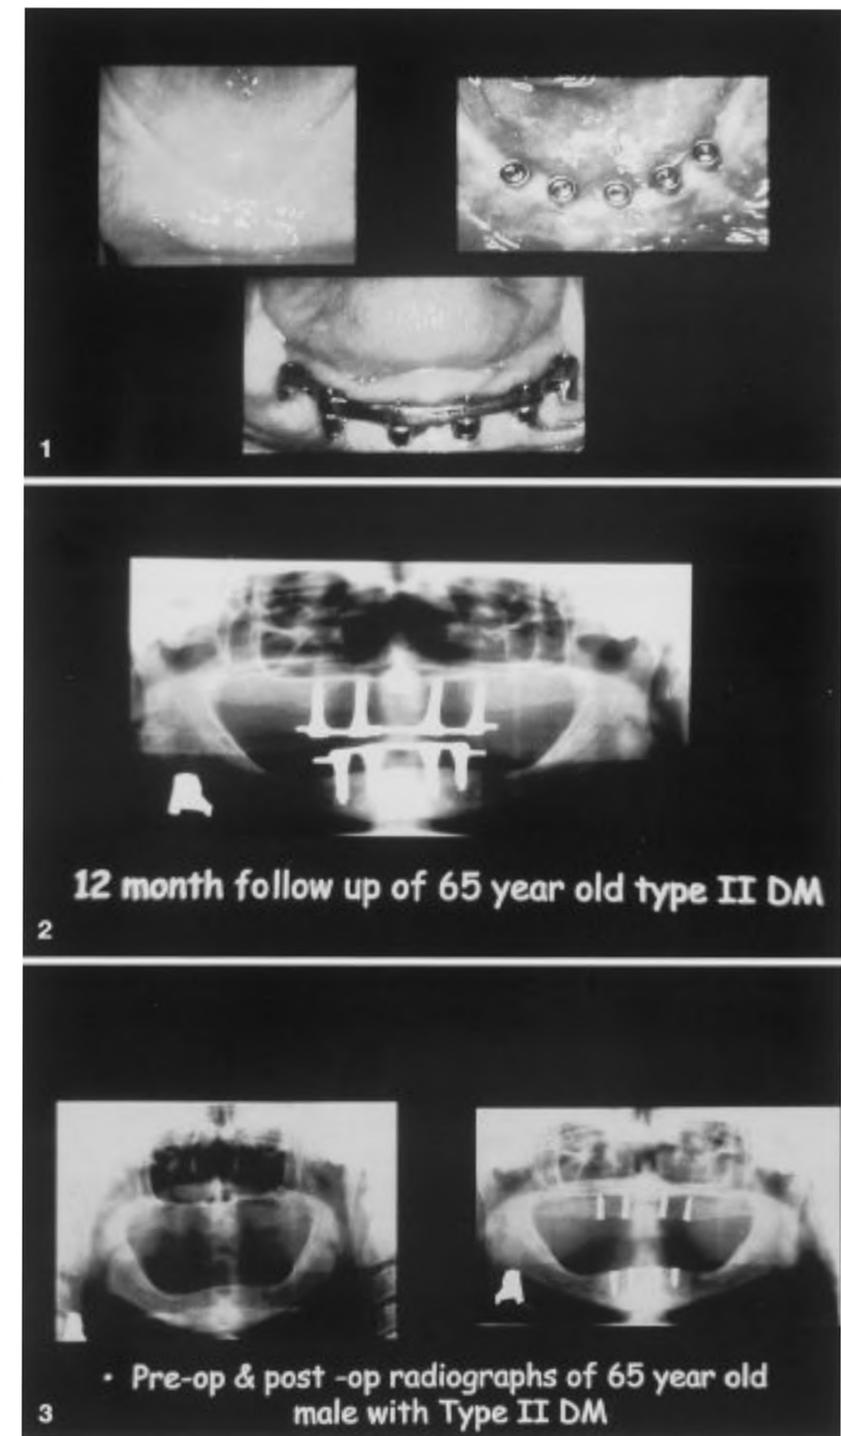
Preoperative and postoperative radiographs of a 65-year-old man before and 6 months after implantation.
